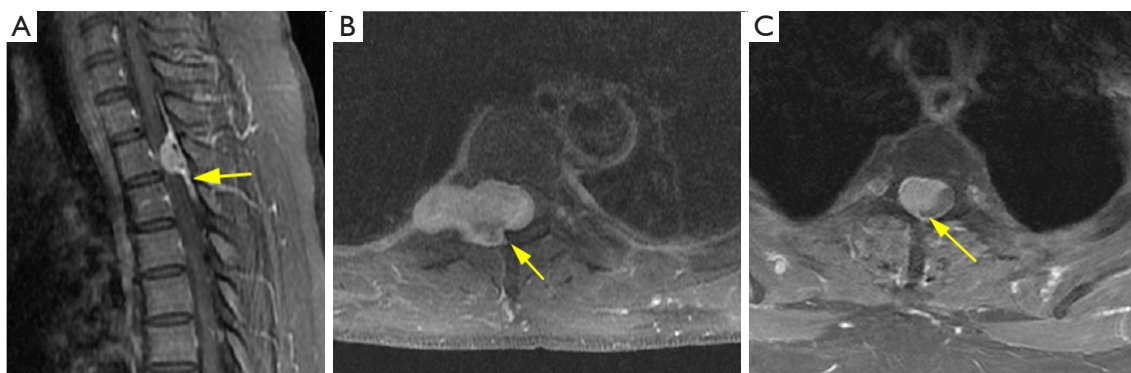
Examples of DTS, IFW, and GLS. (A) A 46-year-old woman with intraspinal meningioma at the T2 vertebra level. Sagittal T1WI enhancement shows the lesion has “dural tail sign” (yellow arrow). (B) A 67-year-old man with intraspinal schwannoma displays a dumbbell shape. Axial T1WI enhancement shows the lesion presenting “intervertebral foramen widening” (yellow arrow). (C) An 84-year-old woman with back pain and discomfort underwent MRI and was pathologically diagnosed as intraspinal meningioma. Axial T1WI with fat-suppressed enhancement displays the meningioma presenting diffuse enhancement and “ginkgo leaf sign” (yellow arrow). DTS, dural tail sign; IFW, intervertebral foramen widening; GLS, ginkgo leaf sign; T1WI, T1-weighted images; MRI, magnetic resonance imaging.
